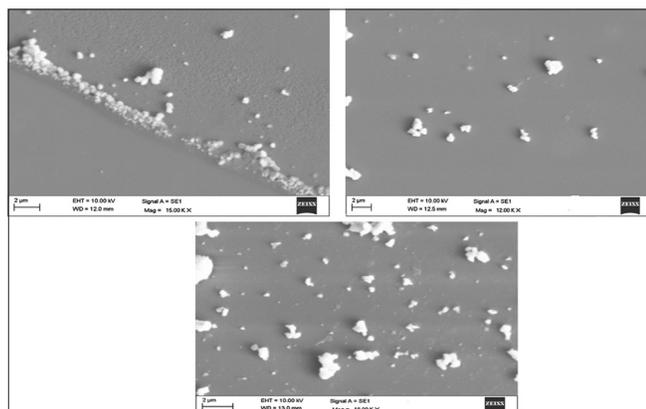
SeNPs after ultrasonic irradiation
